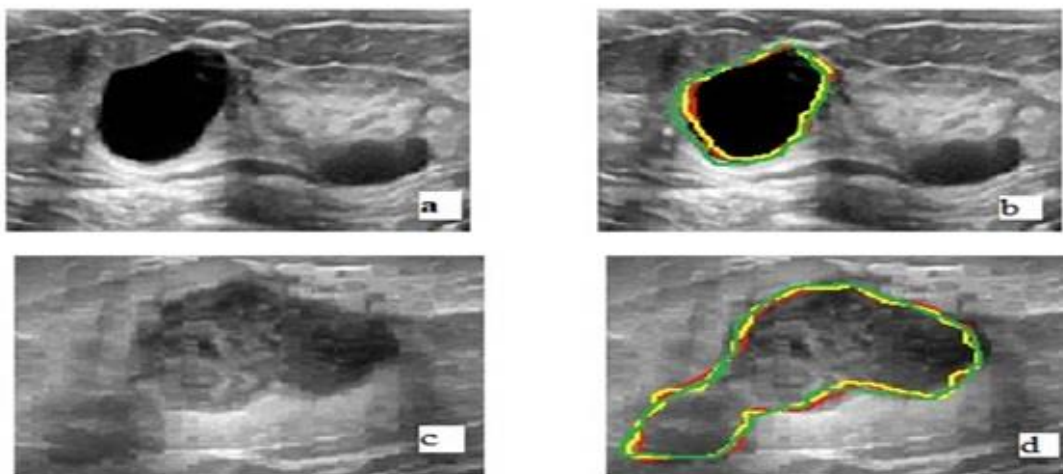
Ultrasound breast Images Mammogram (a) Benign Ultrasound image (b) Benign Ultrasound image with marking (c) Malignant Ultrasound image (d) Malignant Ultrasound image with marking
